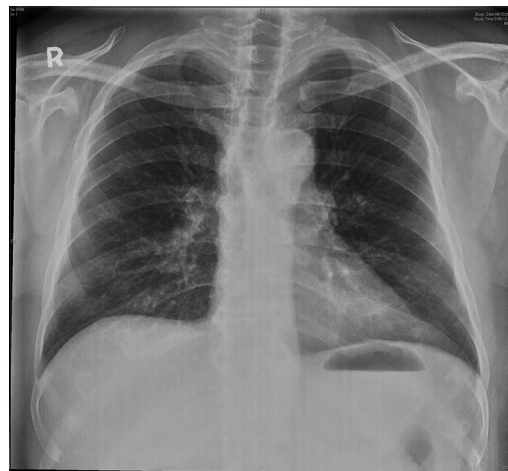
Chest radiograph of patient two at discharge
